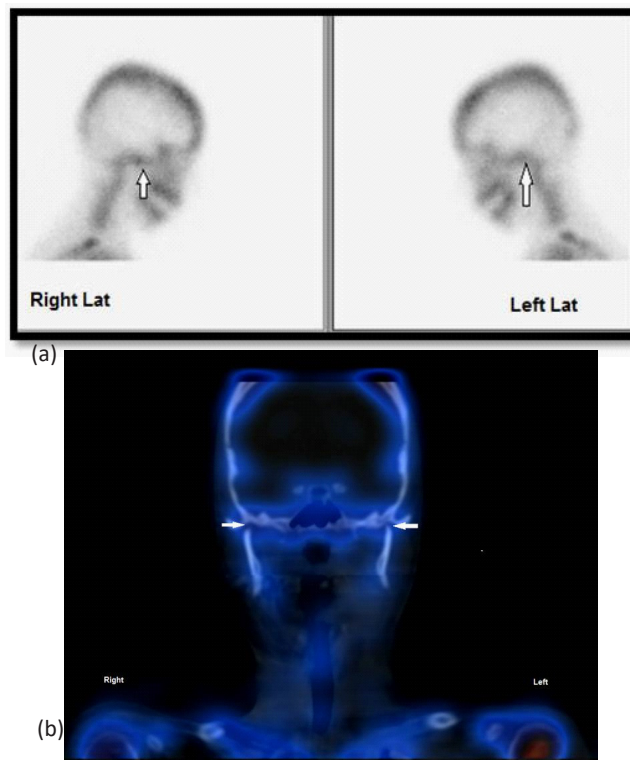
Planar (a) and SPECT CT (b) bone scan images showed bilateral atrophic condyles with no tracer uptake (Arrows).
